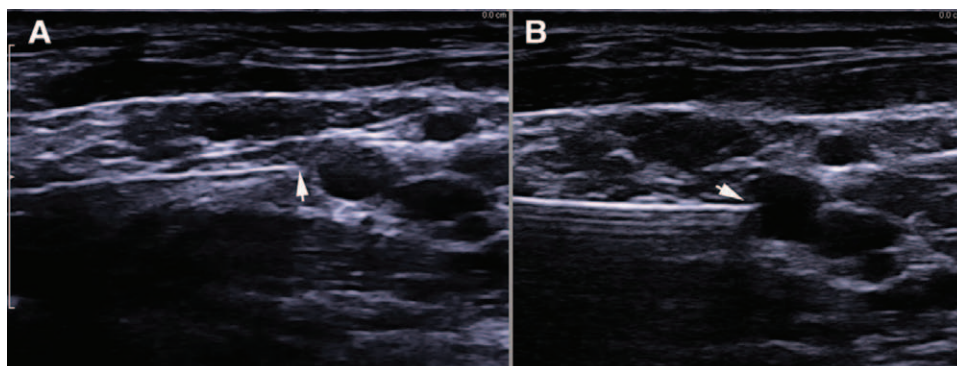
Ultrasound image of needle in relation to C5 nerve root (A) 1 mm away from nerve and (B) gently displacing nerve root. Arrowhead indicates needle tip.
